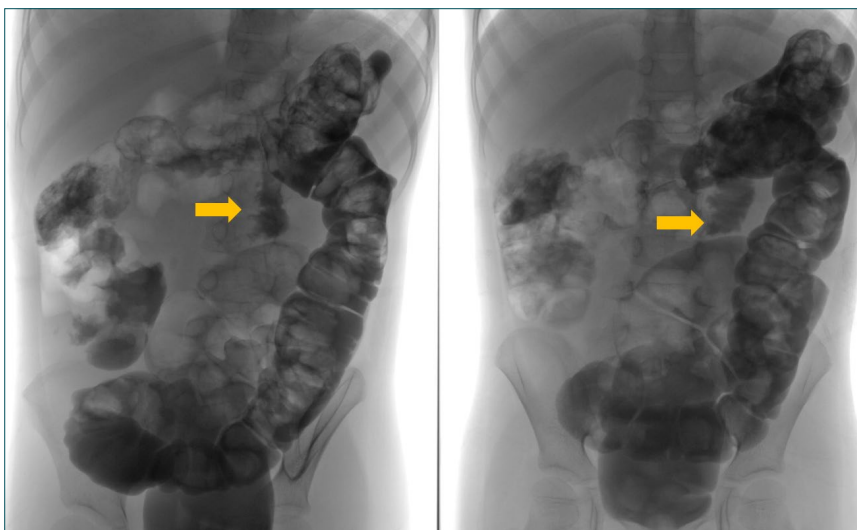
Contrast enema radiography depicting a jejunocolonic fistula.
